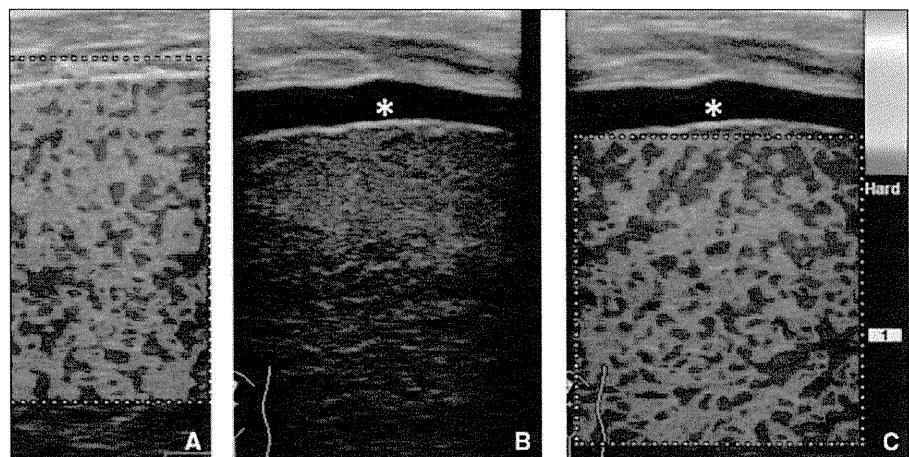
54-year-old man undergoing radiofrequency ablation of hepatocellular carcinoma. A, Tissue elastographic image before injection for artificial ascites shows elastic ratio of 2.79. B, B-mode ultrasound image shows layer of artificial ascites (asterisk). C, Tissue elastographic image shows elastic ratio of 2.80 in presence of ascites (asterisk).
